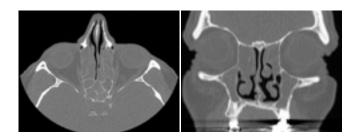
CT-scan of a patient with Nasal Polyposis. Observe the presence of bilateral ethmoido-maxillary opacities and the small width of the olfactory cleft.
